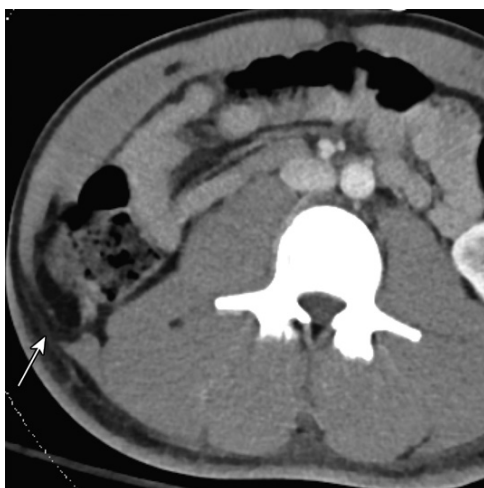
Untreated chronic lumbar hernia in a 27-year-old man after a motorcycle accident. Axial CT image from a whole-body CT examination shows an apparent diastasis of the external oblique from the latissimus dorsi, although without appreciable stranding, a finding suggestive of an old injury (arrow). A review of the patient's medical record disclosed an old stab wound to that area.
